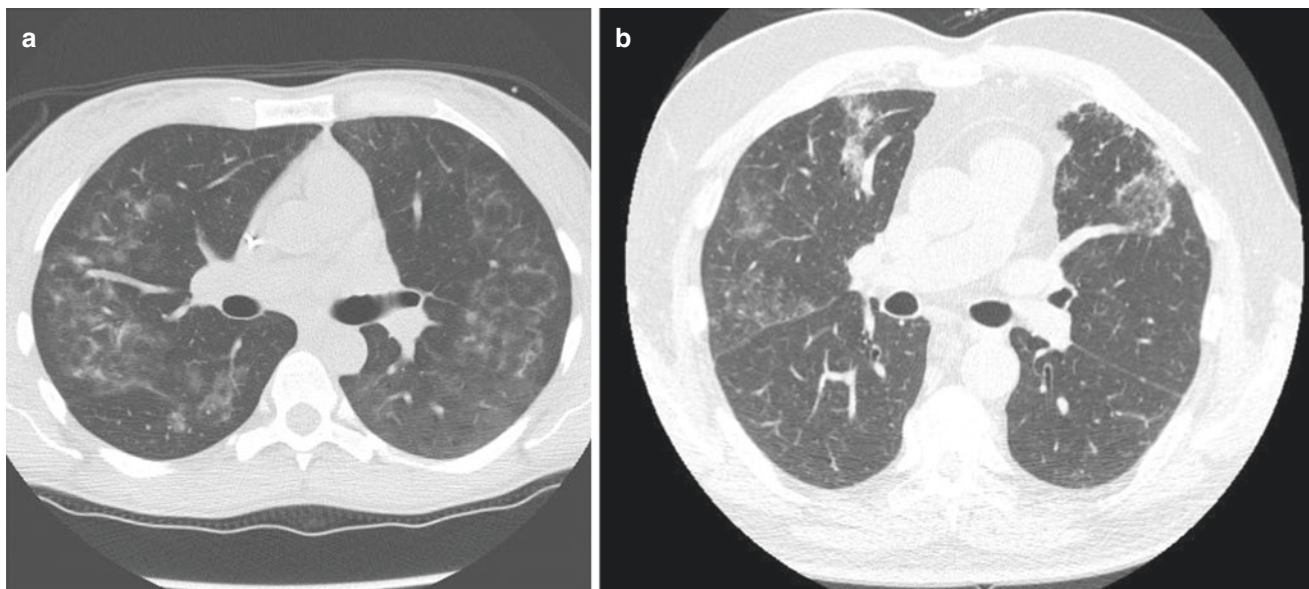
CT demonstrating organizing pneumonia pattern. (a) Ground-glass opacities seen here are nonspecific but often represent an organizing pneumonia. (b) The opacity seen here in the left upper lobe
